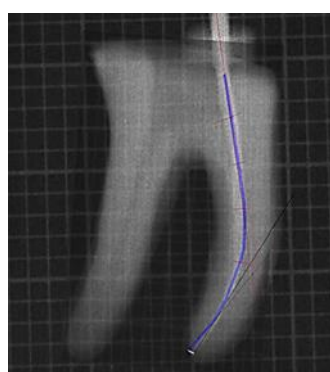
Superimposition of pre and post operative radiographs.
